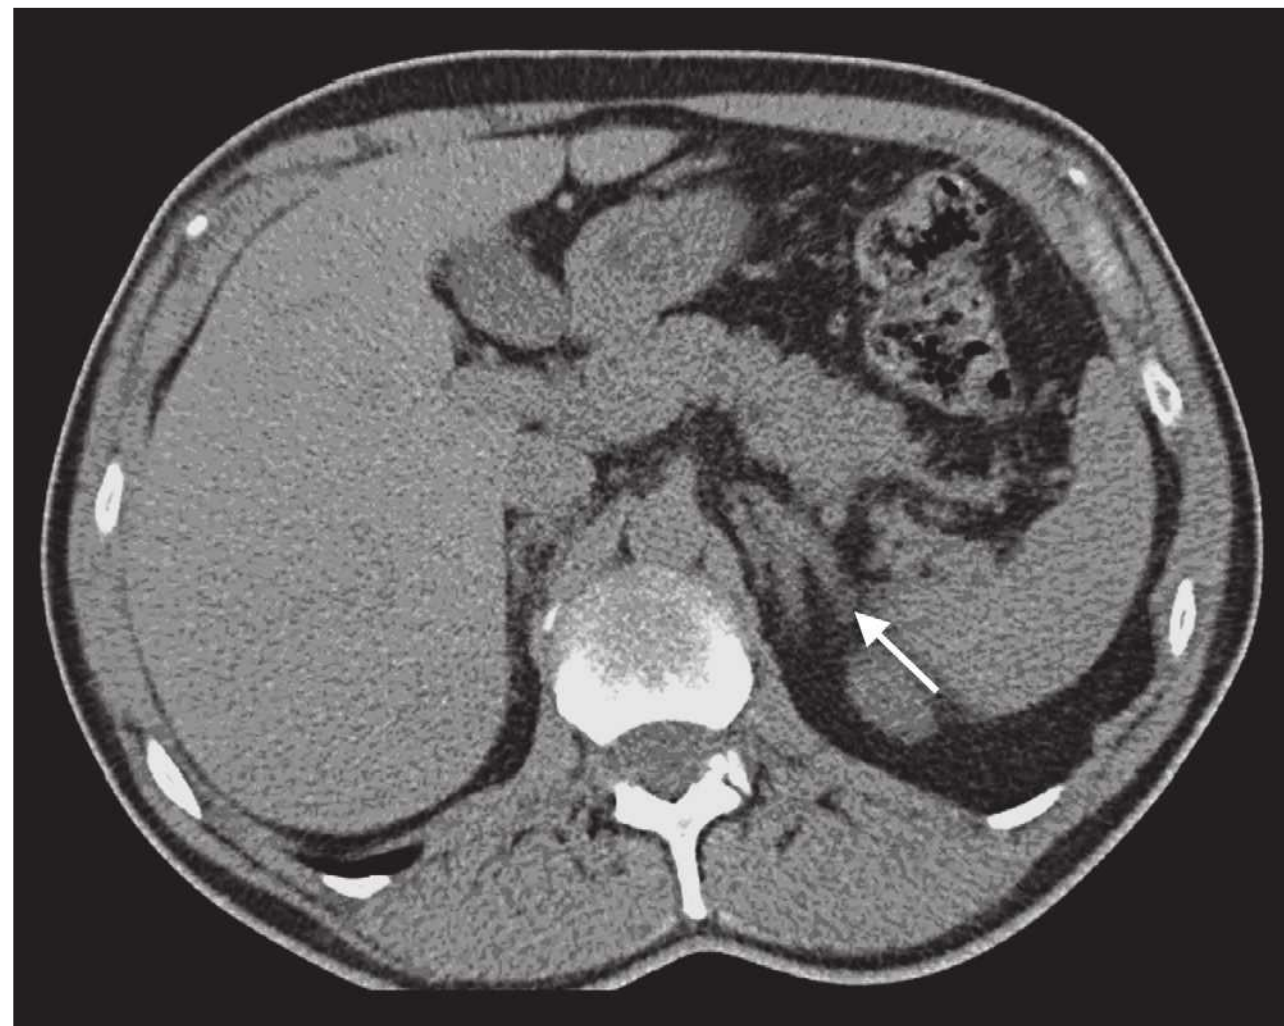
A noncontrast enhanced adrenal computed tomography scan of a patient with clinical characteristics suggestive of primary aldosteronism. There is marked thickening of both limbs of the left adrenal gland without discrete nodules. The right adrenal gland was reported as normal. Adrenal venous sampling (results shown in Table 43.2) showed bilateral secretion of aldosterone, indicating bilateral adrenal hyperplasia.
